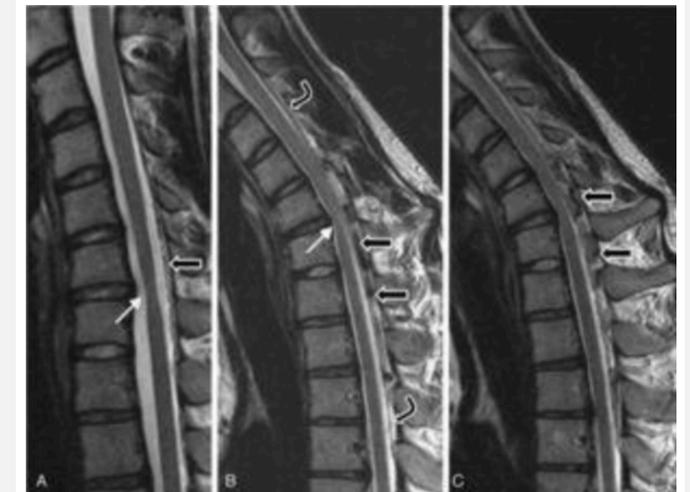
Flexion Based MRI from Agundez et al in a patient with Hirayama Disease.
